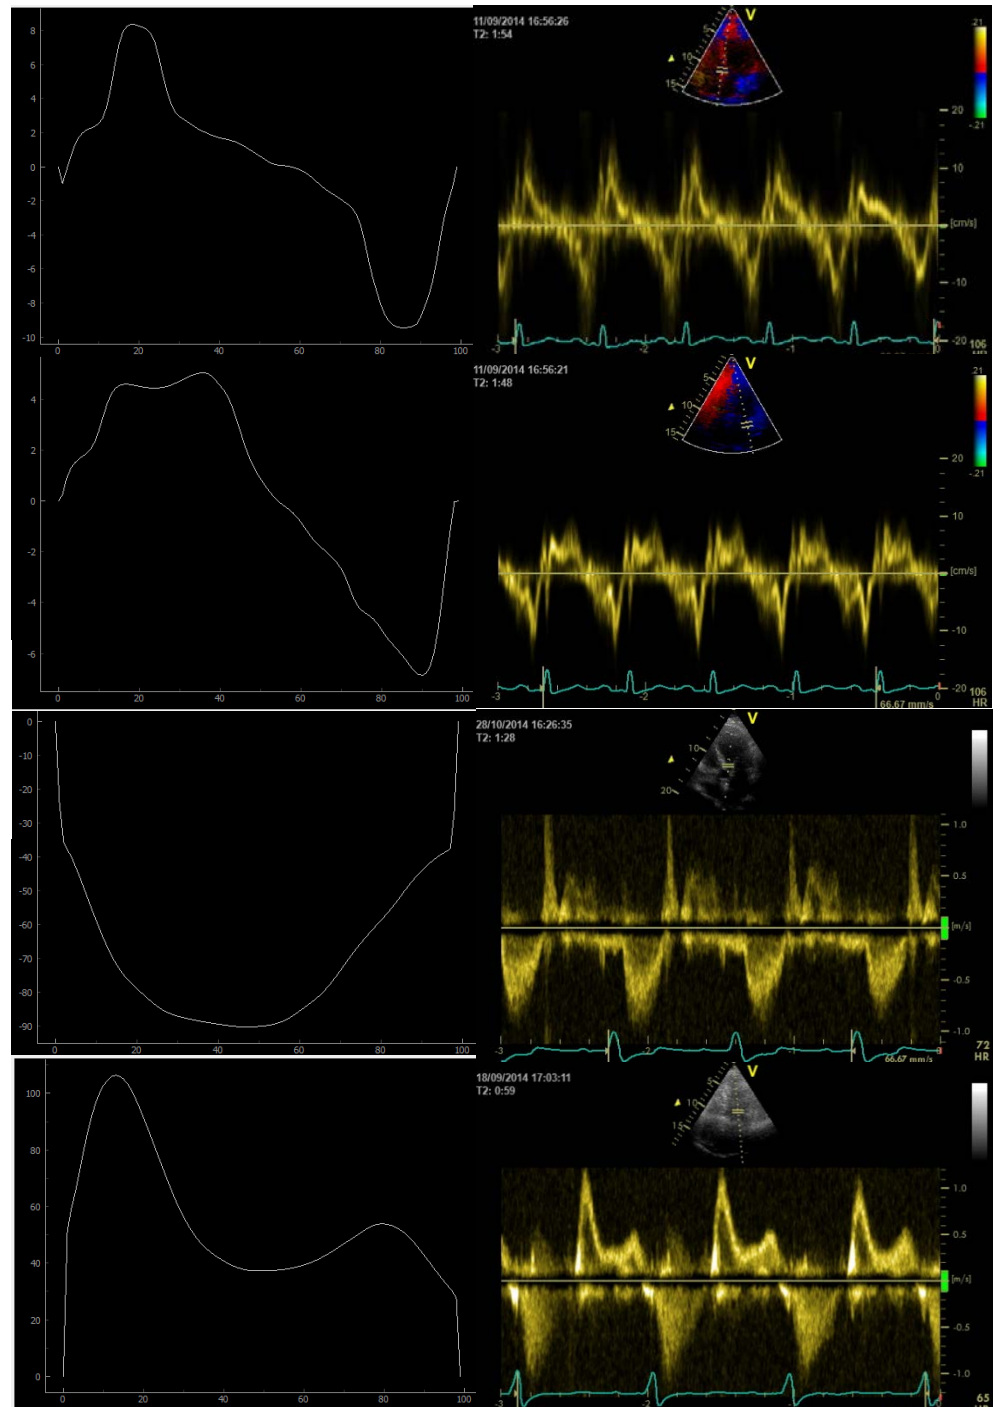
Validation of the Echocardiography Analysis Platform
